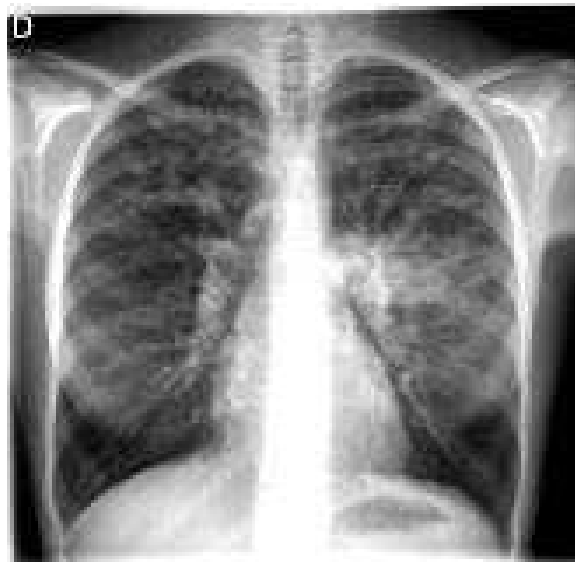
Chest radiography of *M. abscessus* infection in CF patient.
